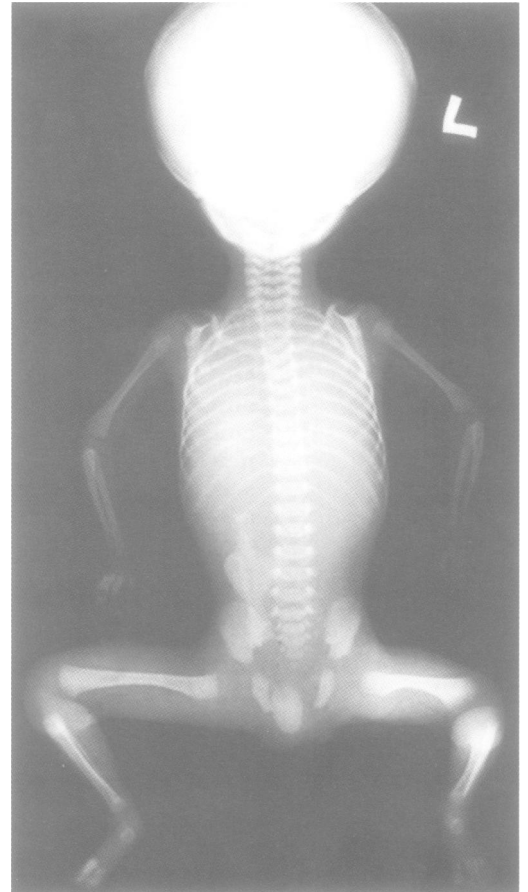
Postmortem radiograph showing normal long bones, ribs, and vertebrae.
